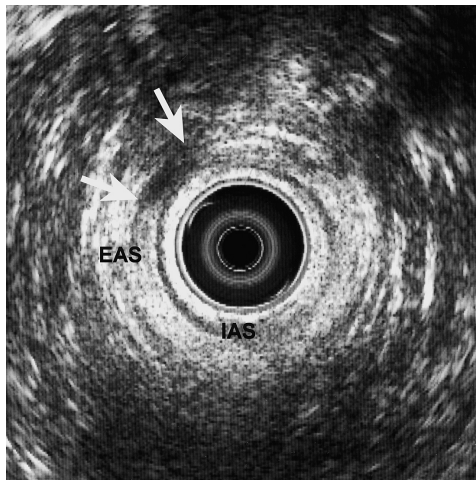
Endoanal ultrasonography of a 38 year old female with a complicated vaginal delivery in medical history. The image demonstrates disruption of the external anal sphincter muscles in the distal anal canal of 30 degrees (white arrows). The top of the figure is anterior. At digital rectal examination no EAS defect was detected.
